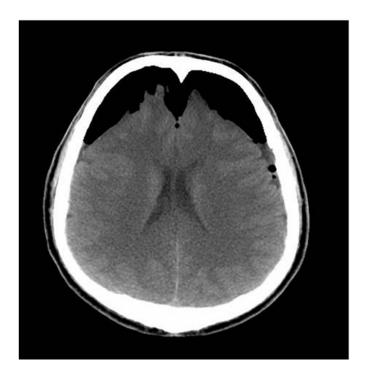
CT scan of brain with mass effect from pneumocephalus (Gokmen et al. 2015)
